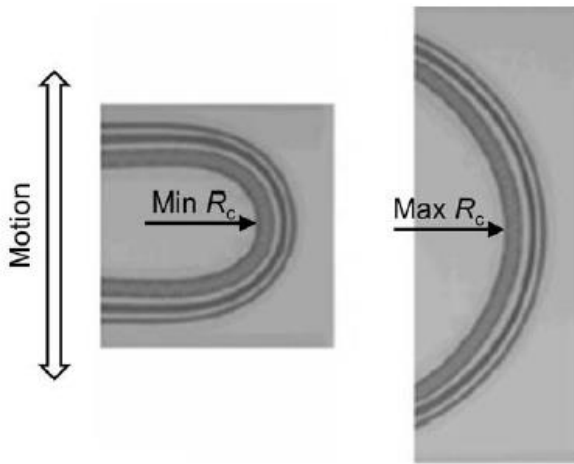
X-ray images showing deformation of the 2014VP lead at maximum (left) and minimum curvature (right) positions. The bench test cycles the lead between these two positions.
